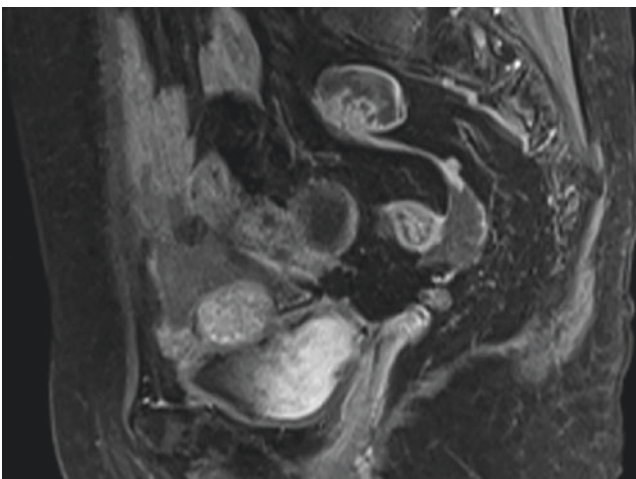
T1-weighted contrast-enhanced image showed the recurrent masses had heterogeneous enhancement
